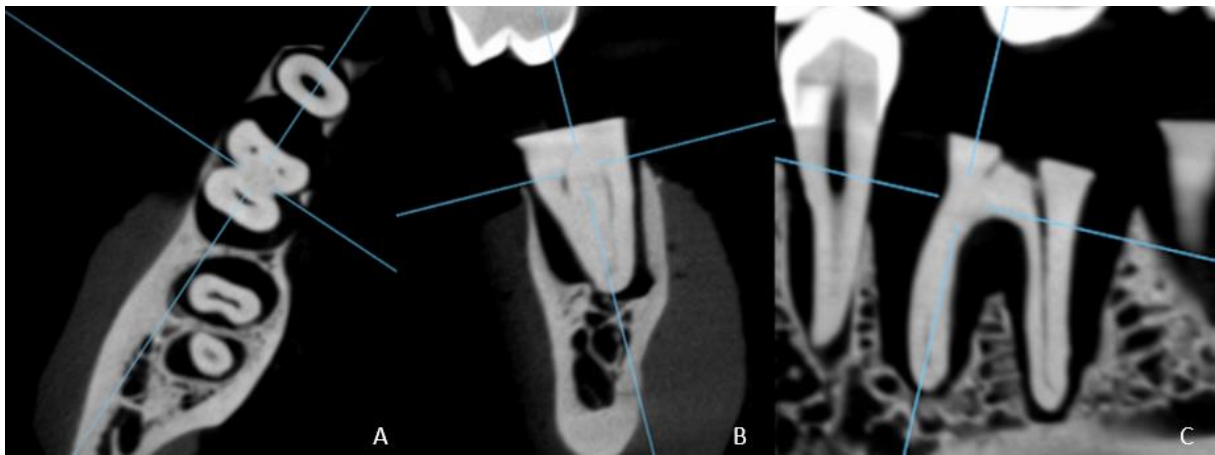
Corrected axial (A), coronal (B) and sagittal (C) sections of CBCT in relation to the long axis of the mesial root of the lower first molar.
